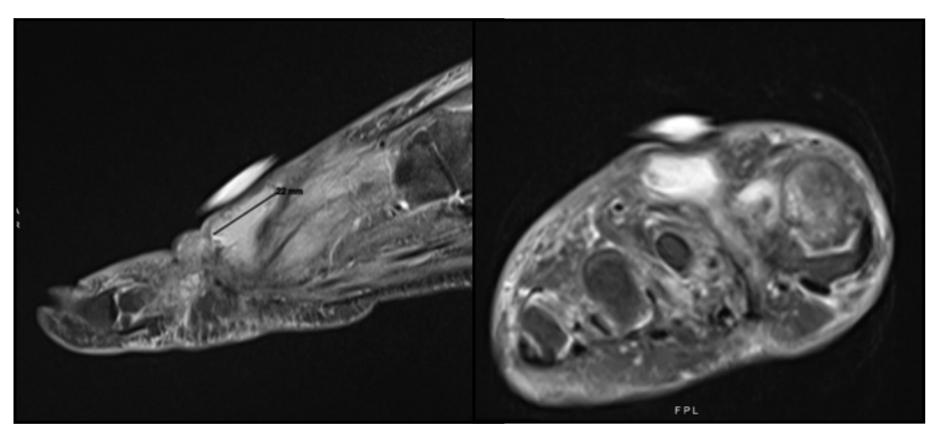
MRI revealing hyper-intense collection extending from dorsal to plantar aspect of foot.
